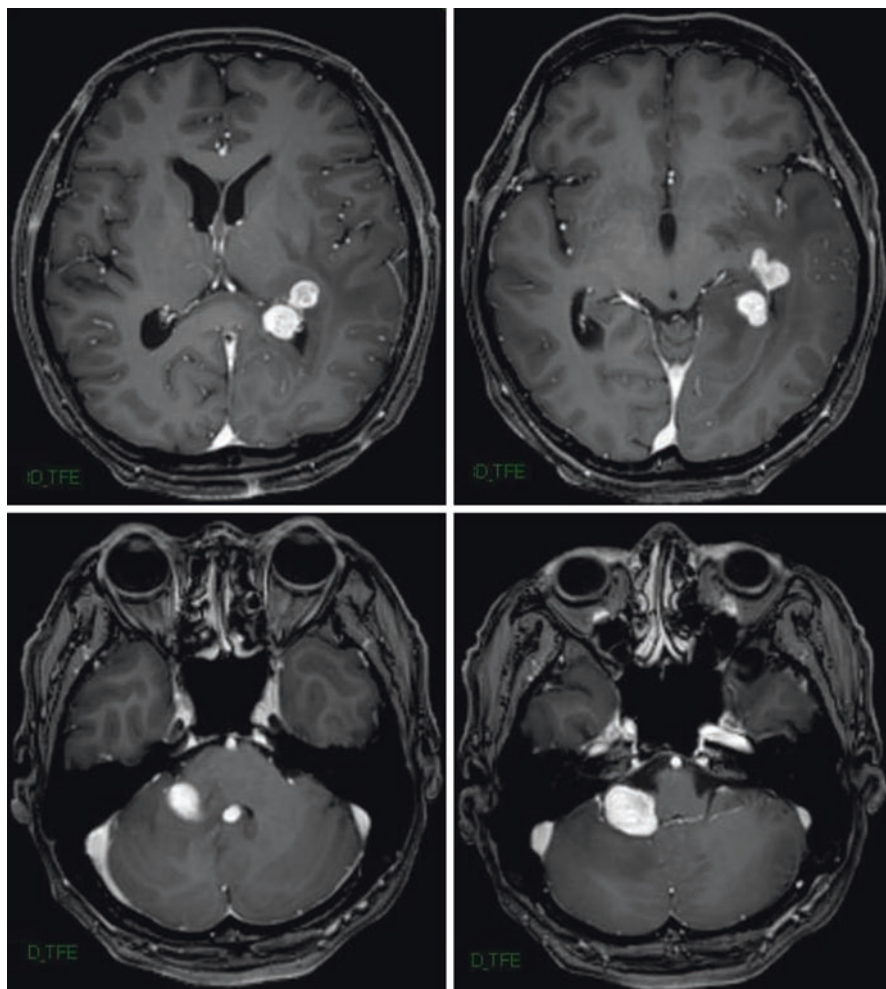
Gadolinium-enhanced MR images of a 58-year-old male with multiple PCNSL presenting with right oculomotor nerve palsy. Two contiguous supratentorial lesions and two contiguous infratentorial lesions are observed. The patient showed symptomatic progression just after one course of high-dose MTX chemotherapy
